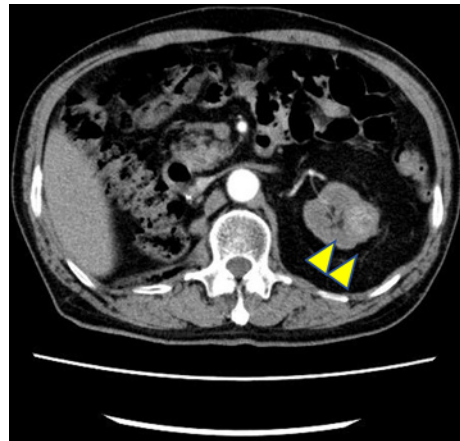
Left kidney tumor on plain CT at the time of first recurrence.
